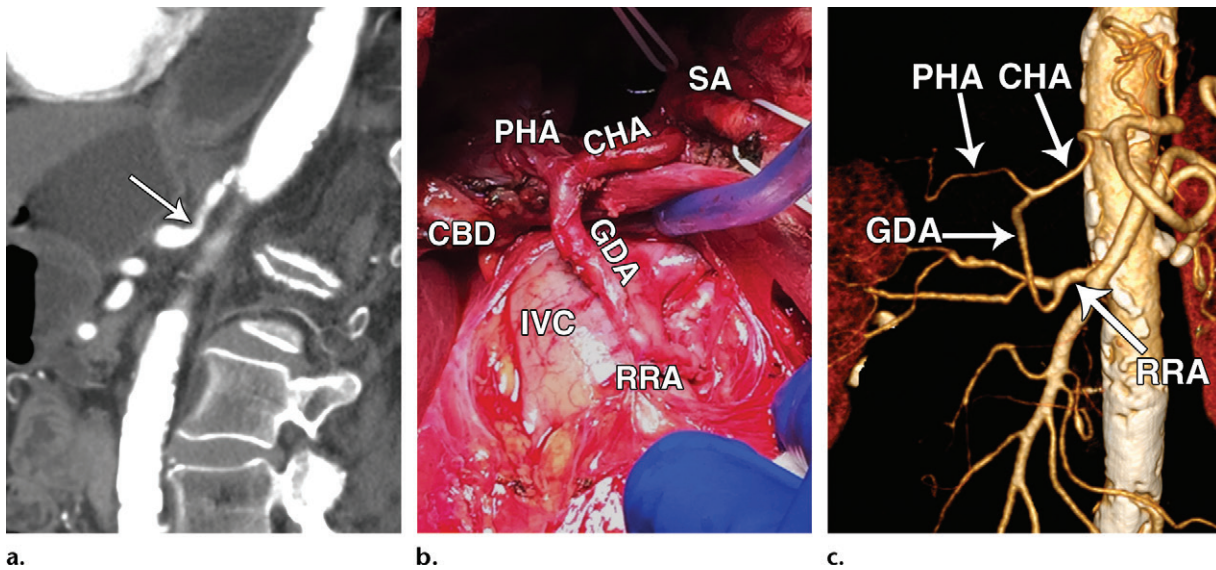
PDAC in the pancreatic head in a 78-year-old woman. (a) Sagittal CT image shows celiac artery stenosis (arrow) with poststenotic dilatation. During surgery, the common hepatic artery was hypotrophic, the gastroduodenal artery was engorged, and when clamped, the proper hepatic artery pulse notably diminished, findings that are indicative of dependence on blood flow to the liver through the gastroduodenal artery. (b) Intraoperative photograph after pancreaticoduodenectomy was performed shows an end-to-side anastomosis between the gastroduodenal artery (GDA) and the right renal artery (RRA). CBD = common bile duct, CHA = common hepatic artery, IVC = inferior vena cava, PHA = proper hepatic artery, SA = splenic artery. (c) Postoperative volume-rendered CT image shows the successful arterial reconstruction 1 month after the Whipple procedure. CHA = common hepatic artery, GDA = gastroduodenal artery, PHA = proper hepatic artery, RRA = right renal artery.
